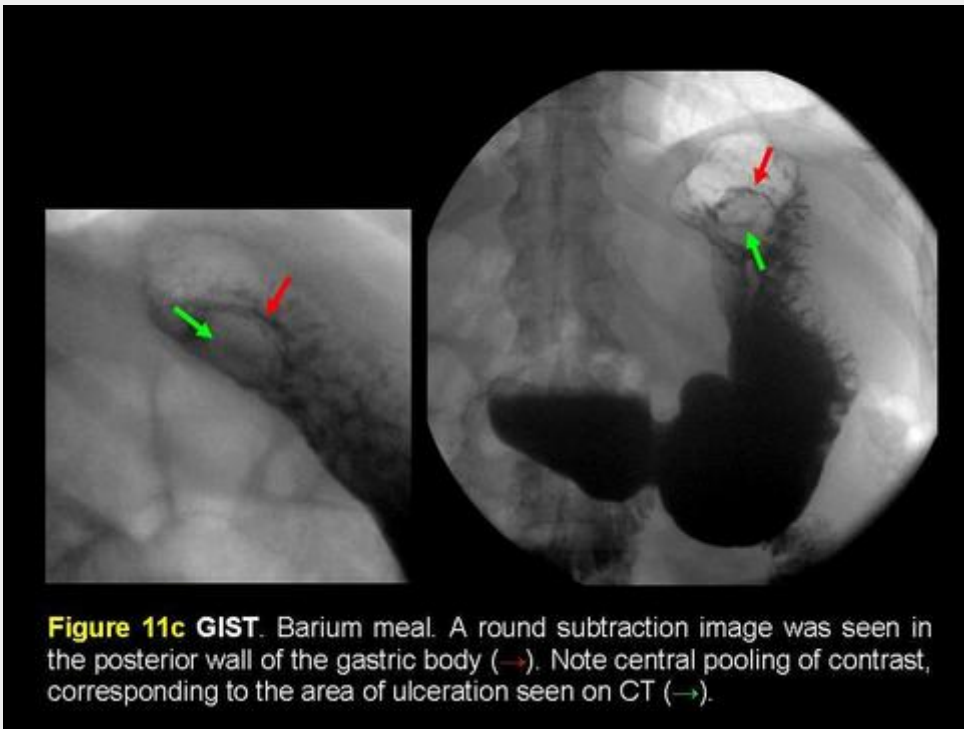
GIST. Barium meal. A round subtraction image was seen in the posterior wall of the gastric body (→). Note central pooling of contrast, corresponding to the area of ulceration seen on CT (→).
